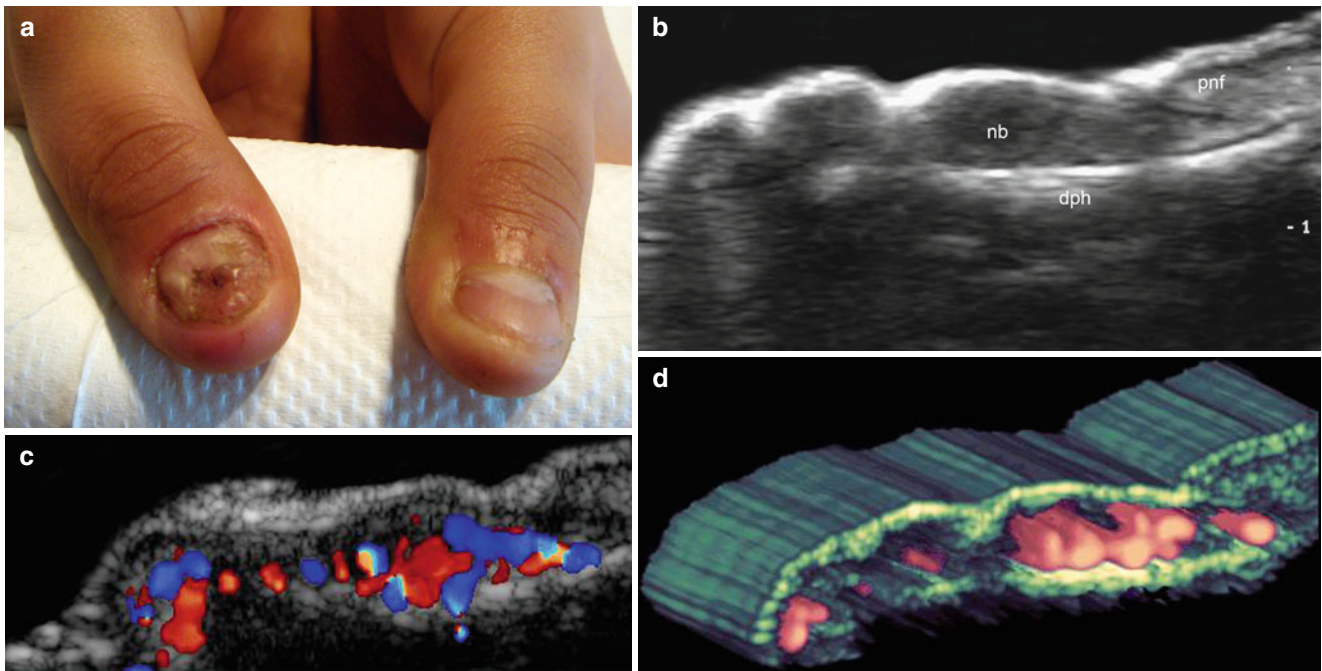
(a–d) Granuloma. (a) Clinical image shows swelling and dystrophic changes in the nail of the right thumb. (b) Grey scale ultrasound image (longitudinal view) shows thickening and hypoechogenicity of the nail bed that also affects the matrix region. Notice the wavy shaped nail plate with loss of the bilaminar pattern. (c) Color Doppler
